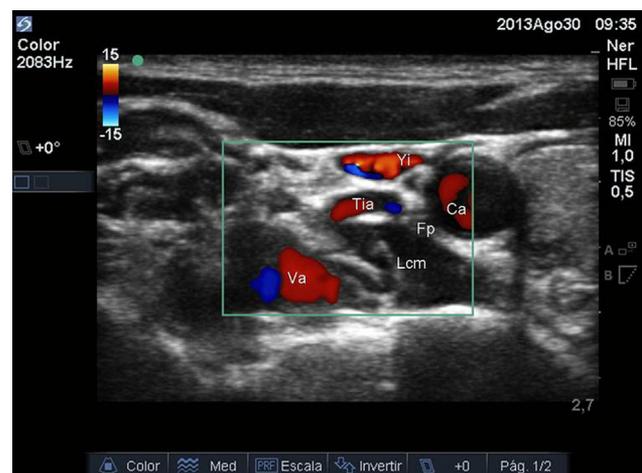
Ultrasongraphic image with color Doppler showing the inferior thyroidal artery (ITa), prevertebral fascia (Fp), vertebral artery (Va), longus colli muscle (LC), internal jugular vein (IJ), and carotid artery (Ca). (Color version of figure is available online.)
